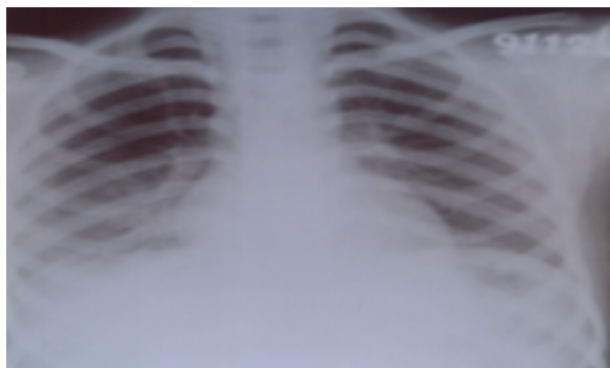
X-ray chest show normal air bronchogram CASE-1.
